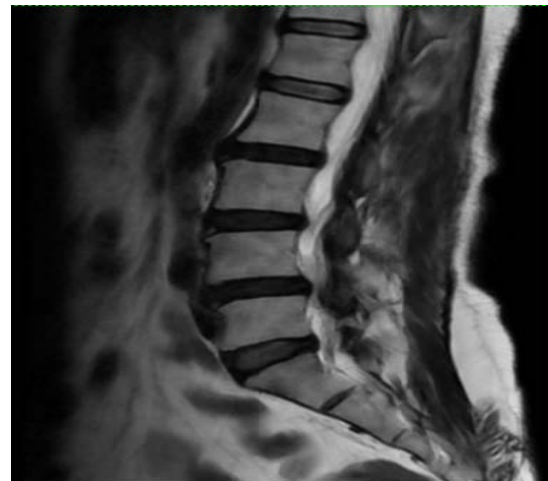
Sagittal T2-weighted image of the lumbosacral spine demonstrates Grade I anterolisthesis of L4 over L5 with bilateral facet joint arthropathy. At the L3–L4 level, a left postero-central annular tear is noted. There is diffuse disc bulge with associated dehydration changes, causing ventral thecal sac indentation and bilateral neural foraminal narrowing, with indentation of the left exiting L4 nerve root.
